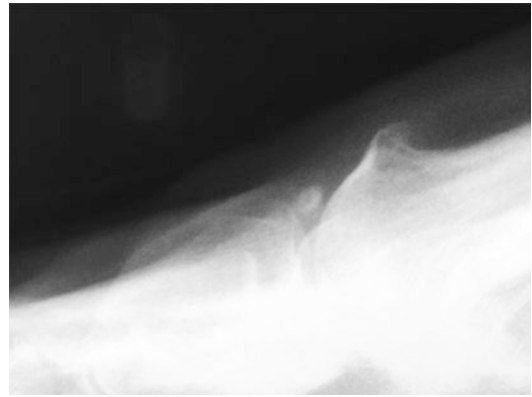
X-ray (lateral view) in a hallux rigidus (first degree) plus intraarticular loose body
